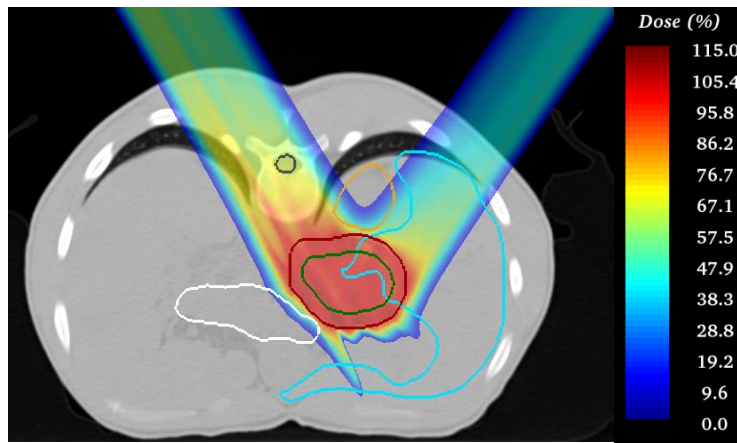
Dose distribution of a planning-CT for Patient F. (Contoured OARs and target volumes: grey = spinal cord, mustard = right kidney, white = bowel, aqua = liver, green = CTV, red = PTV)
